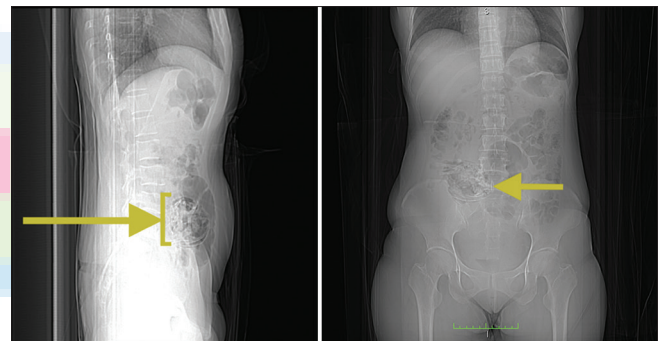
Sagittal and coronal views of the patient's abdominal x-ray showing the bony fetal calvarium (yellow arrows) along the right lower abdomen
